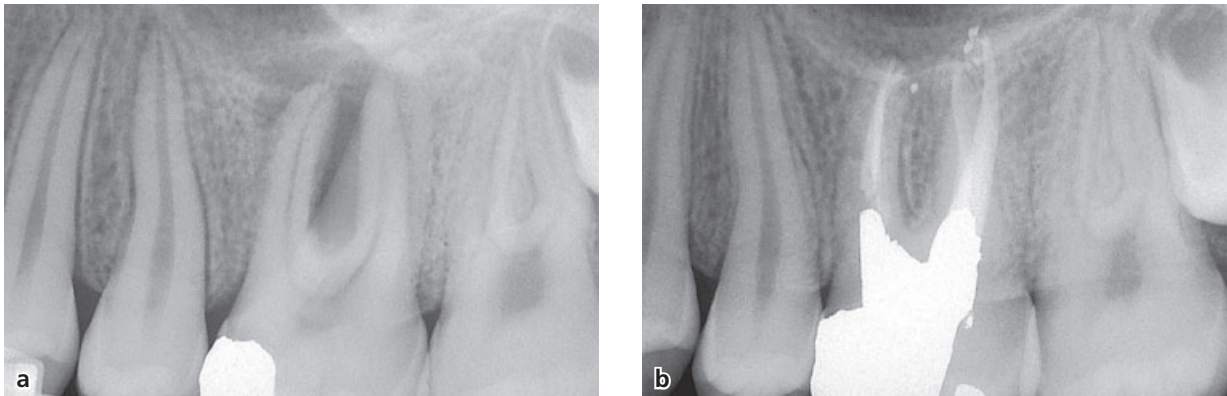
(a) Radiograph demonstrating a destruction of inter-radicular bone and the presence of periapical defects at the mesial and distal roots of a maxillary first molar. (b) Radiographic appearance of complete healing of the inter-radicular and periapical lesions after endodontic treatment.
